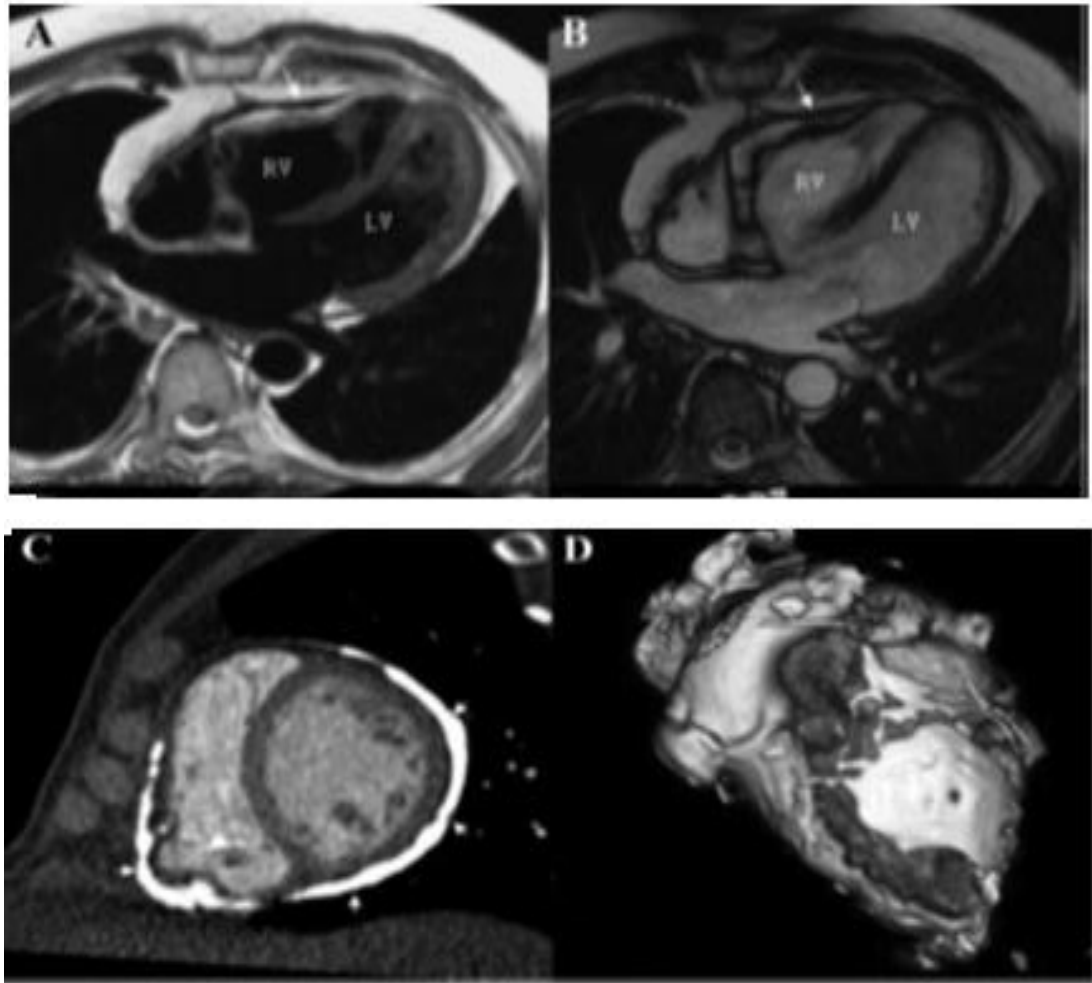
Classic anatomic findings of pericardial constriction by CMR. *Cardiac magnetic resonance findings of constriction demonstrated in black blood T2-weighted spin-echo (A) and steady-state free precession sequence cine sequence (B) in the horizontal long-axis view. Pericardial thickening (6 mm) is seen adjacent to the right atrium and ventricle (arrow), with characteristic tubular deformity of the right and left ventricles (RV/LV) and dilation of the right atrium. (C) CMR demonstrating the presence of circumferential pericardial calcification on a multiplanar reconstructed short-axis image (arrows). (D) Three-dimensional volume-rendered imaging showing the extent and anatomic distribution of pericardial calcium (Verhaert et al., 2010).*
